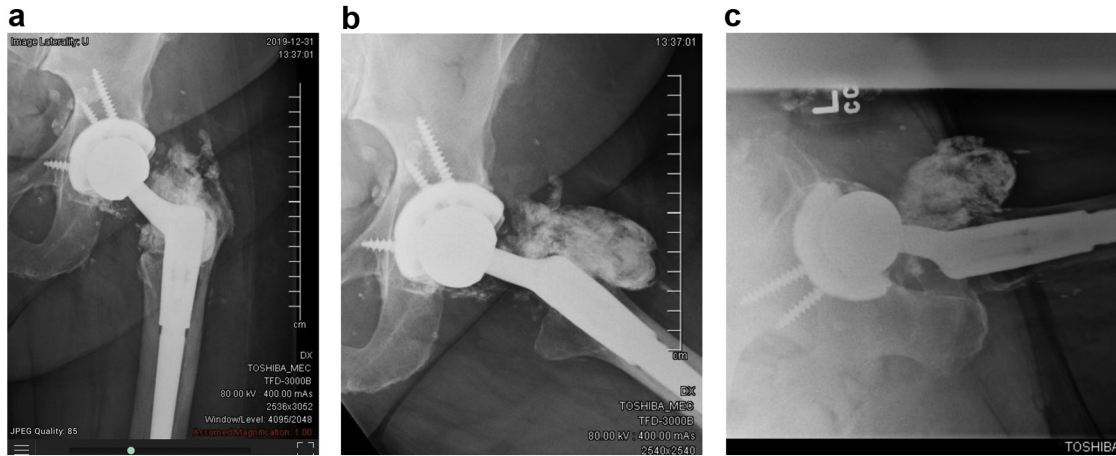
Postoperative anteroposterior (a), frog lateral (b), and cross-table lateral (c) radiographs after synovectomy and revision to a new acetabular component and modular tapered stem.
